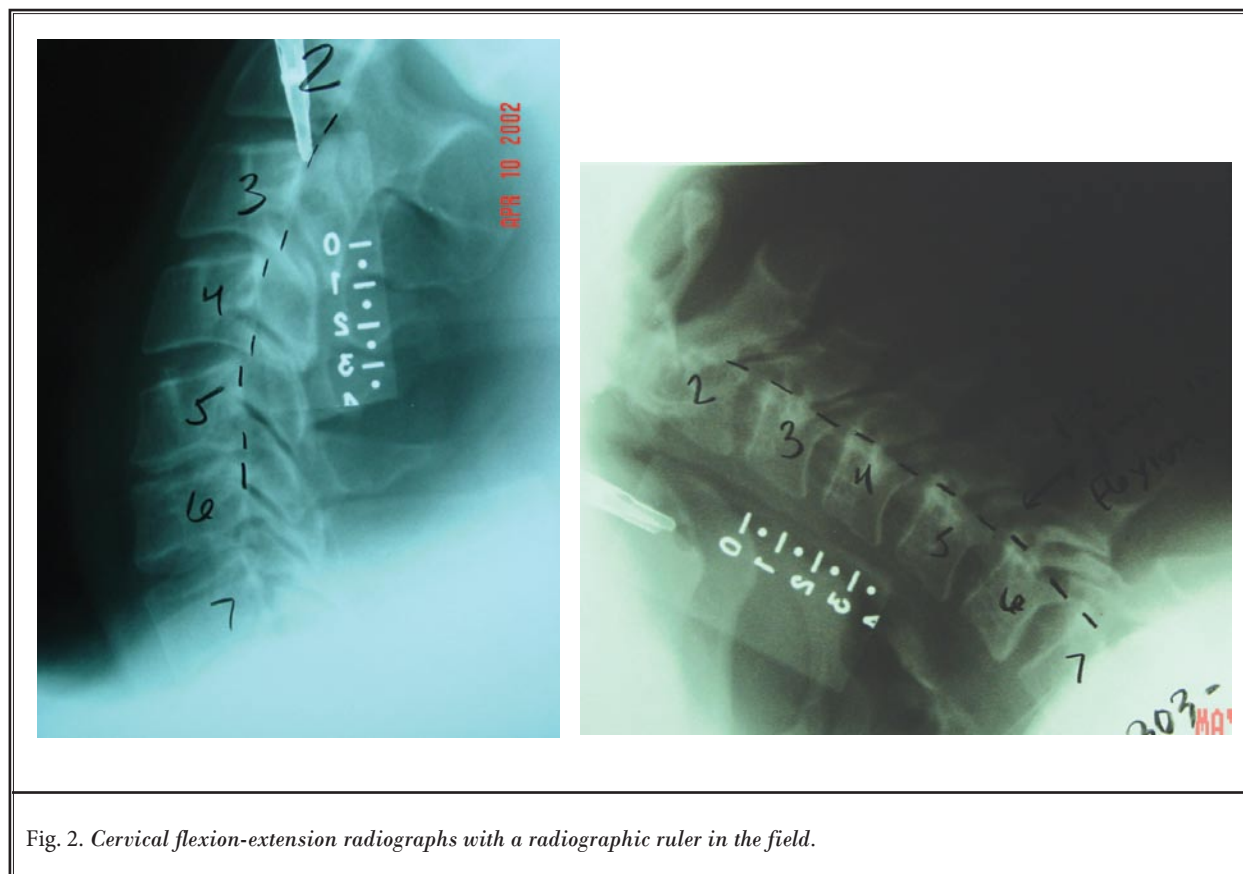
Cervical flexion-extension radiographs with a radiographic ruler in the field.
